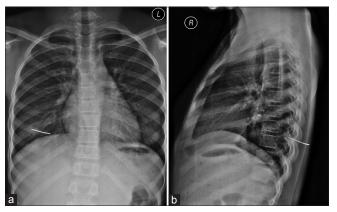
(a) Frontal chest radiograph shows a linear metallic opacity overlying the right lung base. (b) Lateral chest radiograph shows the needle embedded deep in the soft tissue posteriorly
